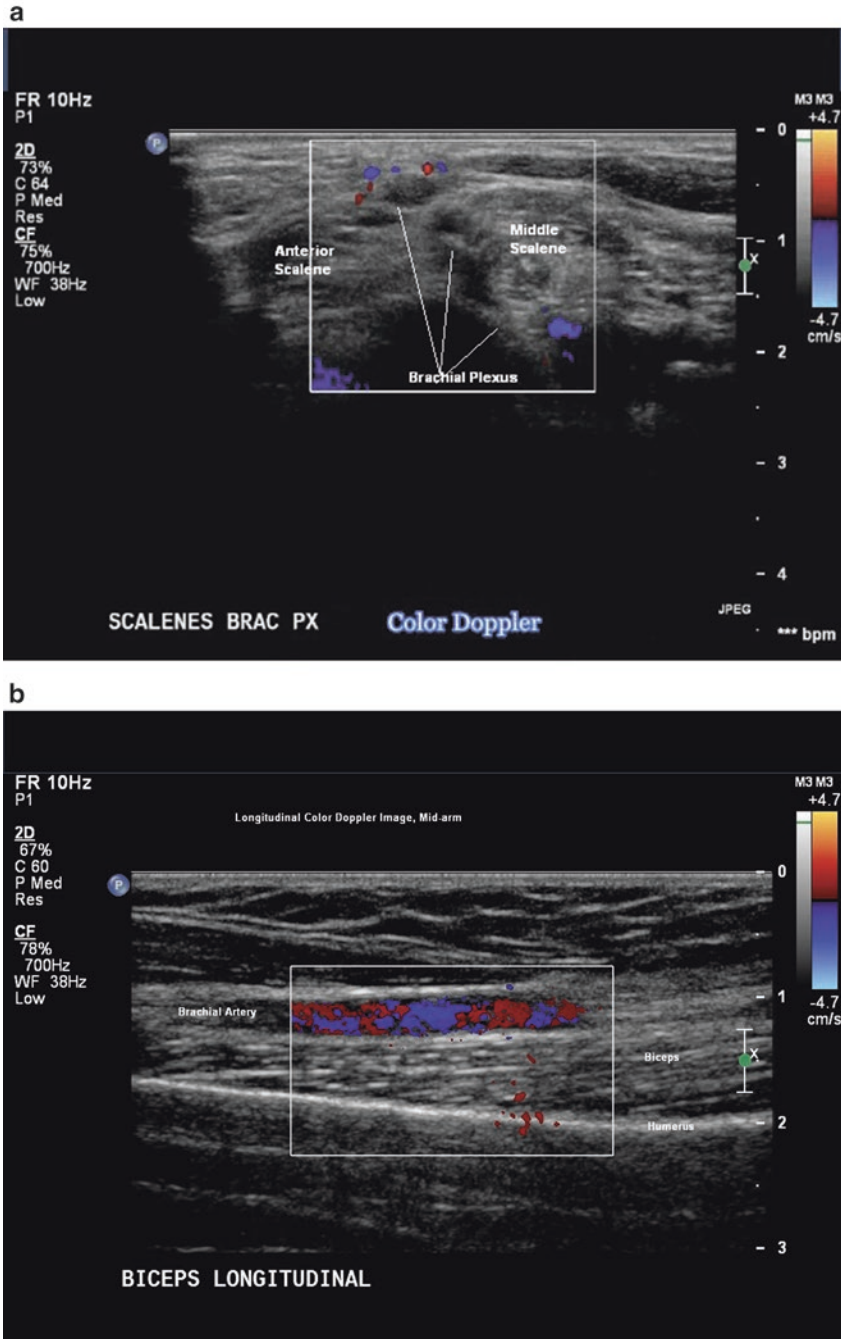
(a) Transverse Color Doppler images inter-scalene triangle, (b) longitudinal Color Doppler image, mid-arm, brachial artery, biceps muscle
